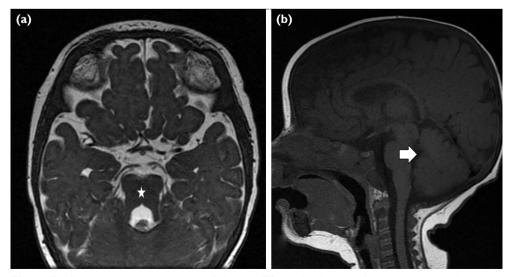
Magnetic resonance imaging of the axial T2-weighted image showing molar tooth appearance of the mid-brain (white star) (a), and the sagittal T1-weighted image showing vermis hypoplasia of the case 3 (b).
